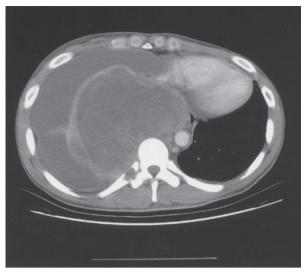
Chest computed tomography scan reveals a $13.4 \times 11.0 \text{ cm}$ heterogenous soft tissue mass at the right posterior mediastinum. The tumor invaded the right lung and pleura, compressed the right heart and esophagus, and destroyed the posterior part of right 10th rib and 10th vertebra.
